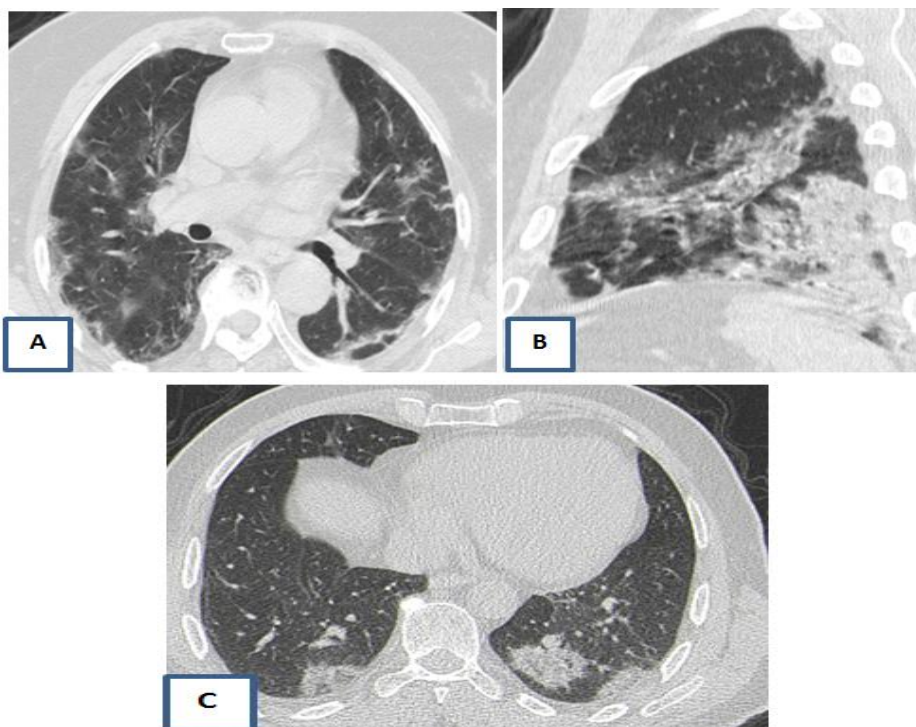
A-Chest CT with axial plane showing bilateral subpleural multifocal patchy consolidations, with lower lobe dominance typical of SARS-CoV2 pneumonia. B-Chest CT with sagittal plane showing band subpleural consolidations. C -Chest CT with axial plane showing minimal nodular consolidations
